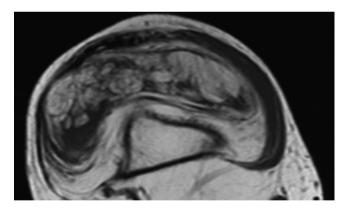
Axial T1-weighted magnetic resonance image reveals frond-like, villous proliferation of fat within suprapatellar synovium, consistent with lipoma arborescens
